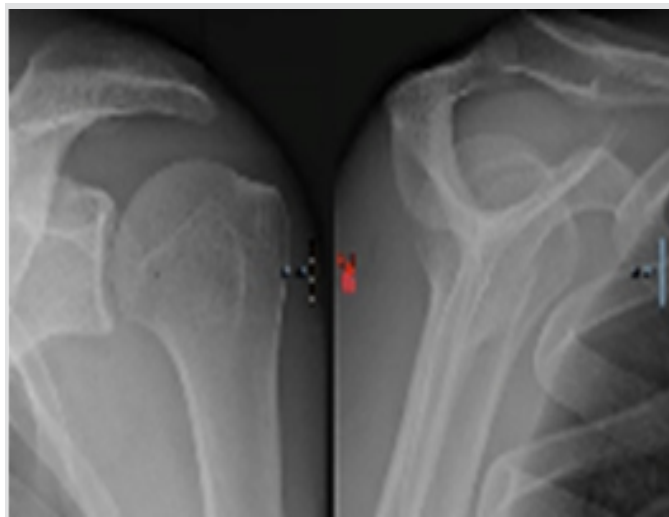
Standard X-rays after the injury.
